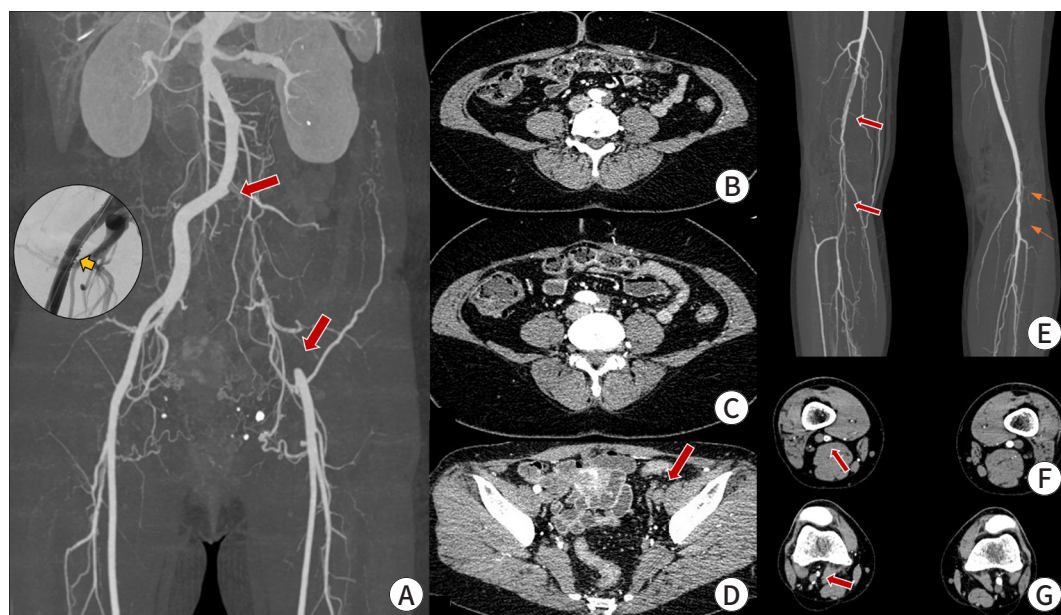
CT angiography findings of the lower extremities. (A) The left iliac artery is completely occluded from the aortic bifurcation (circle; "string of beads" appearance of the right external iliac artery from invasive angiography). (B) Atherosclerotic plaques are present in the abdominal aorta and (C) at the bifurcation site. (D) A thread-like hypoplastic left iliac artery is visible. (E-G) Multiple layers of thread-like stenosis (red arrows) and a beaded appearance of the left popliteal artery are evident on CT angiography (orange arrows).
